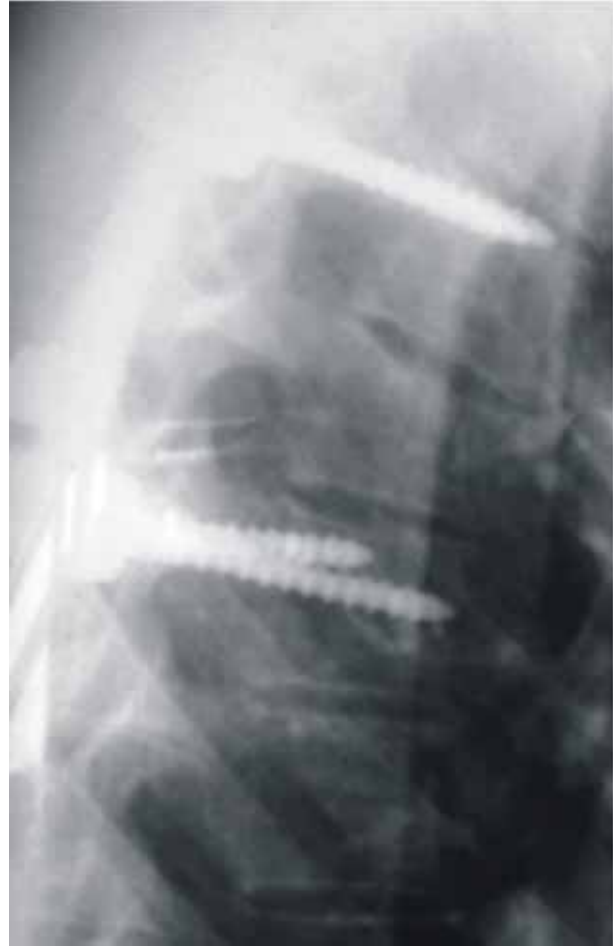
Lateral thoracic radiography: posterior transpedicular stabilization.
